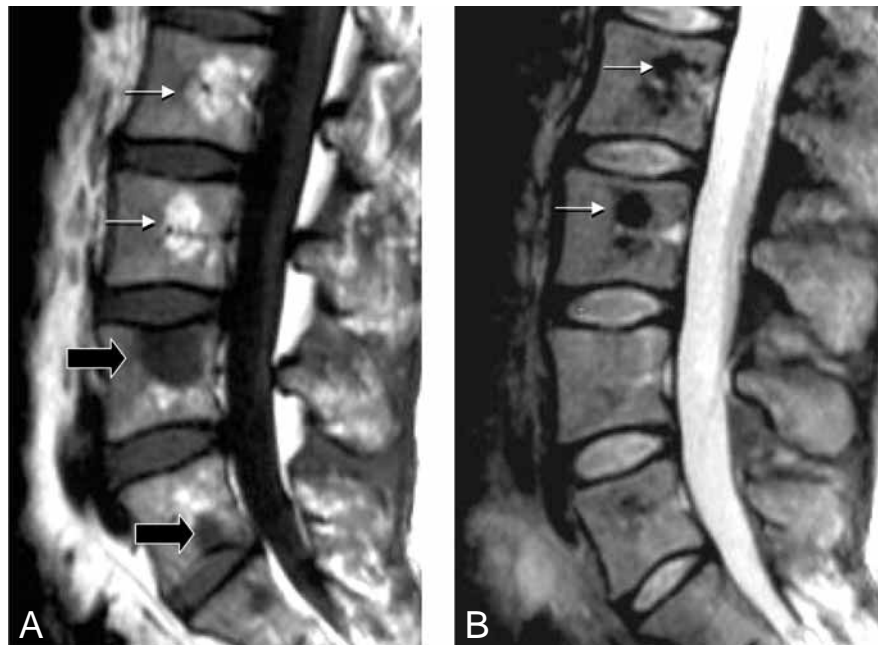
Lesion detection. Sagittal T1-weighted spin-echo MR image of the lumbar spine of a 53-year-old woman with breast cancer shows areas of low signal intensity (marrow replacement- large arrows) compatible with metastases and high signal intensity areas (marrow depletion - white arrows). (b) On the corresponding fat-saturated T2-weighted spin-echo image, the areas of focal marrow replacement are not visible (better detection of lesion on T1- than on T2-weighted images). The low signal intensity areas on the fat-saturated images (white arrows) with high signal intensity on T1-weighted images correspond to areas of fatty marrow and lack clinical significance.
